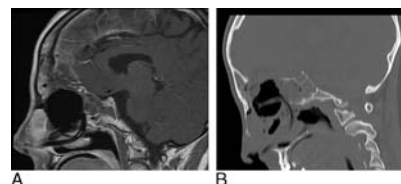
Postoperative T1-weighted sagittal MR (A) and sagittal reconstruction paranasal CT (B) show the gross total removal of lesion.
